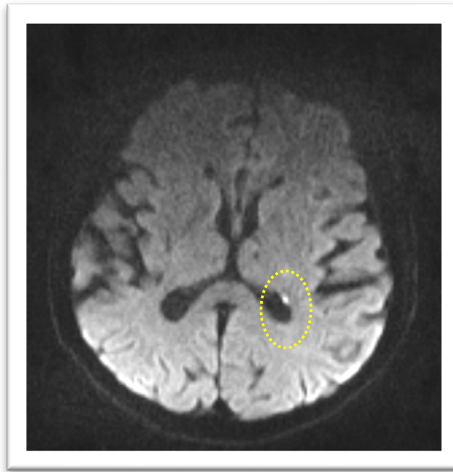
Brain diffusion MRI of Case 6 showing lacunar infarct (as high lighted by yellow dotted circle).
